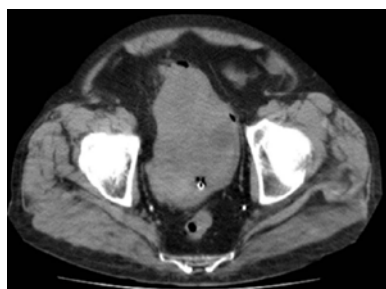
Pelvic CT: Bladder filled with heterogeneous mass.
